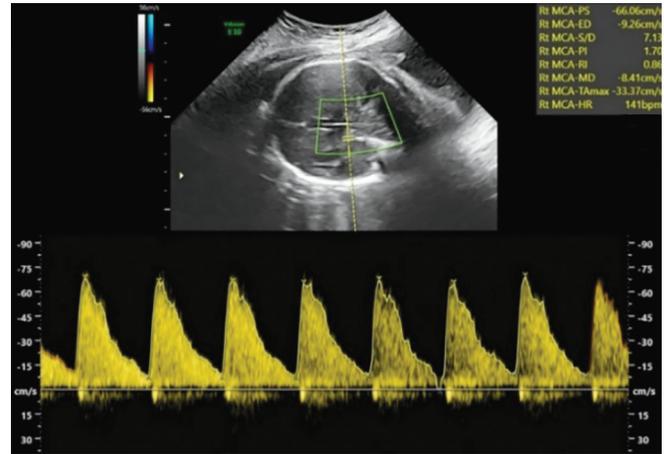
Pretransfusion middle cerebral artery Doppler
